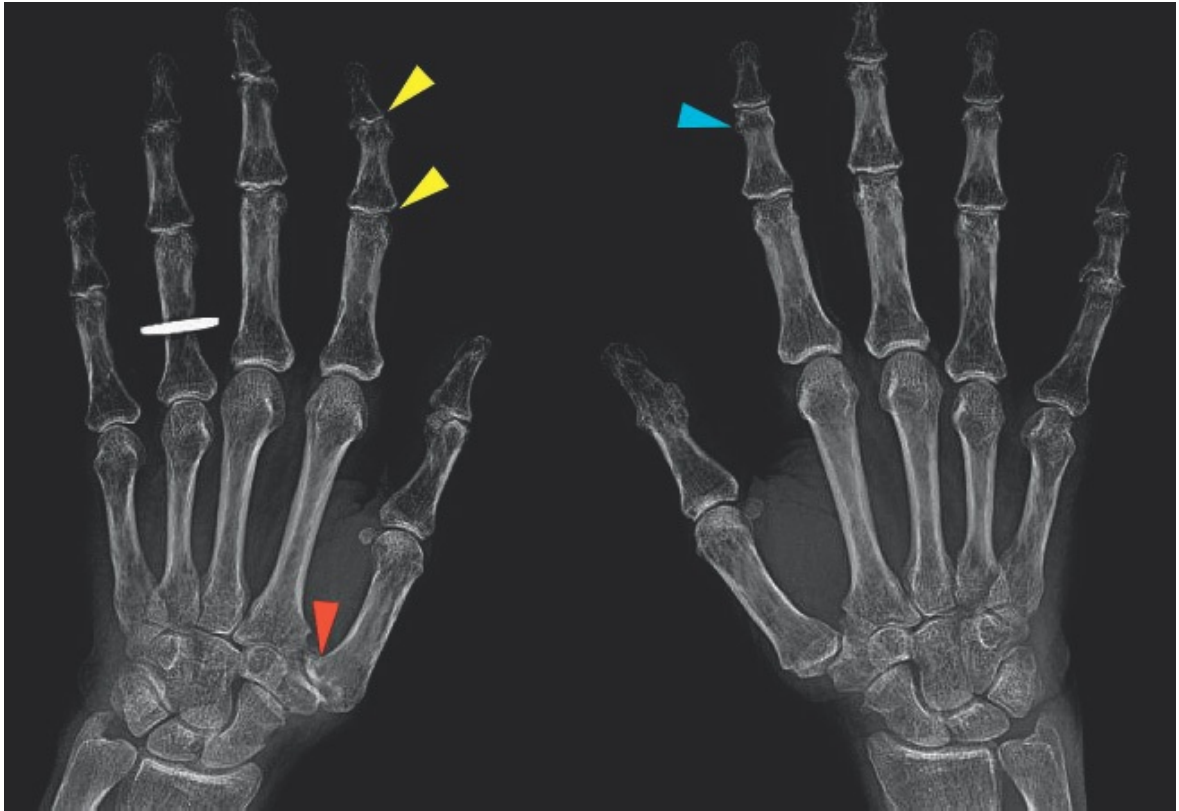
• Radiograph of bilateral hands displays typical characteristics of osteoarthritis, including joint space narrowing (*yellow arrowheads*), osteophyte formation (*blue arrowhead*), and subchondral cyst and associated sclerosis (*red arrowhead*).
